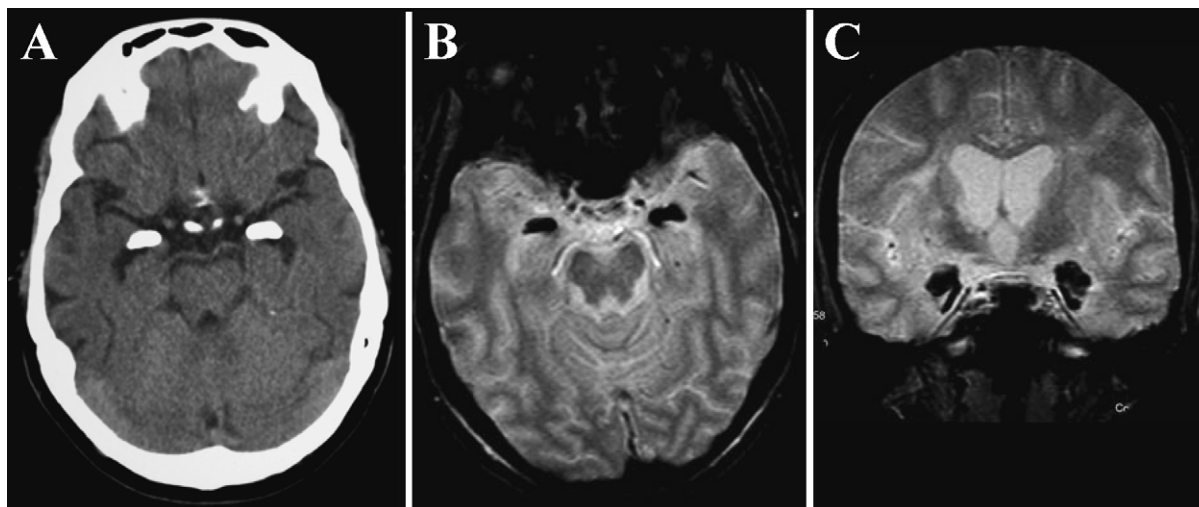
(A) Axial non-contrast CT scan at the level of the midbrain. There are bilaterally symmetric horn-like calcifications within the medial temporal lobes involving the amygdaloid complex. (B and C) Axial (B) and coronal (C) gradient echo T2*-weighted MRI (FLASH, TR 800 ms, TE 15 ms) reveal bilaterally symmetric hypointense areas immediately anterior to the temporal horns of the lateral ventricles. On the coronal image, the downward extension of the calcifications into the parahippocampal gyrus and the uncinate process is clearly seen.
